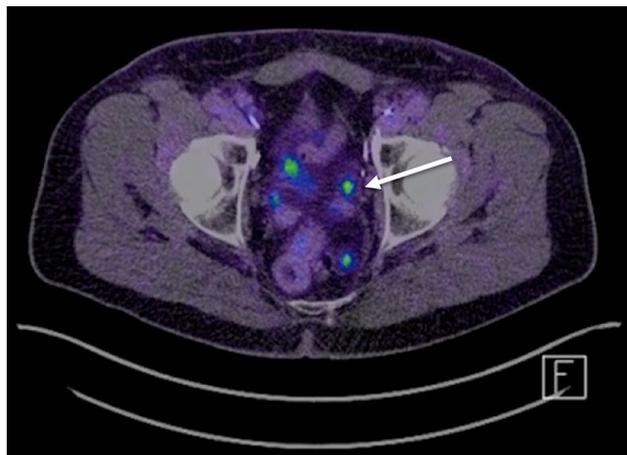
PSMA-PET/CT identifying nodal metastasis (white arrow) in a patient with biochemical recurrence of prostate cancer following prostatectomy
